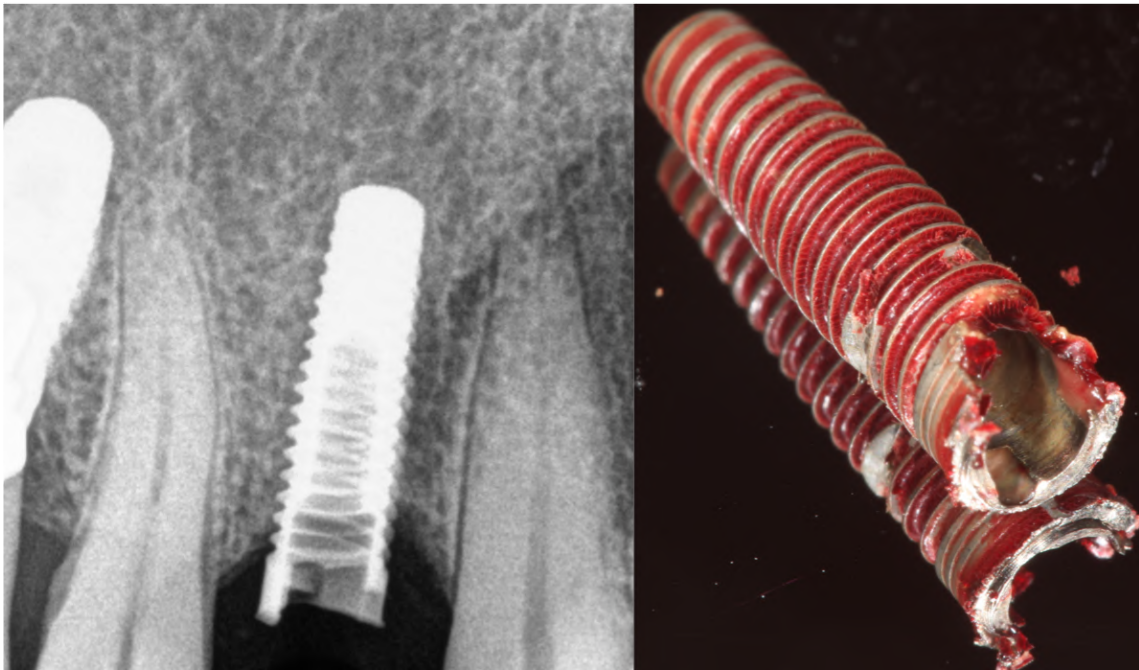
Radiographic and clinical aspect of a dental implant with a platform fracture. Bone loss up to the vertical level of the fracture is clear in the radiograph. Original picture.
